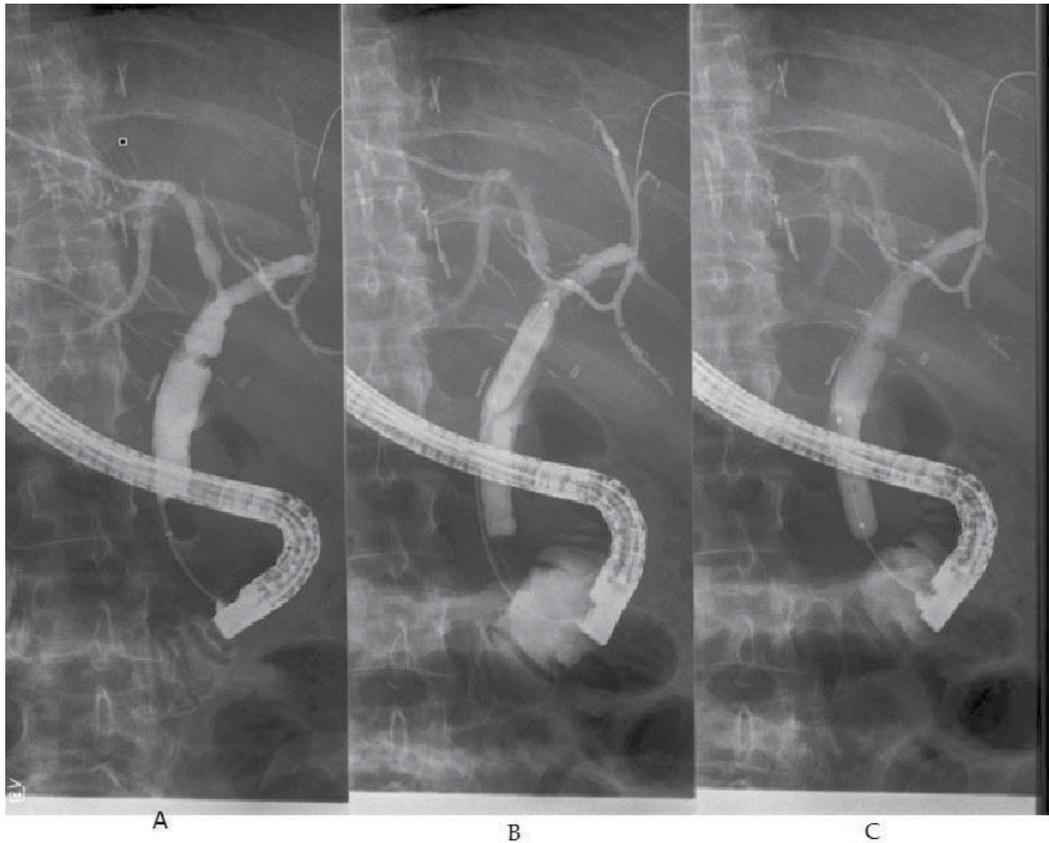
Example of anastomotic stricture after cadaveric liver transplantation. A 57 year old man affected by alcoholic cirrhosis underwent a liver transplant nine months before presenting with elevation of the serum total bilirubin and alkaline phosphatase. An abdominal Doppler ultrasound revealed normal portal vein, hepatic veins and hepatic artery flow with mild dilatation of the intra-hepatic bile ducts. An endoscopic retrograde cholangiography (ERC) was ordered to assess the biliary tree and revealed the presence of a critical anastomotic stricture (Figure 5A, white arrow). An inflatable endoscopic balloon measuring 10 mm in diameter and 4 cm in length was used to dilate the anastomotic stricture for 5 minutes (Figure 5B, white triangle). After dilating the anastomotic stricture, an occlusive cholangiogram revealed an almost complete resolution of the anastomotic stenosis (Figure 5C, white arrow).
